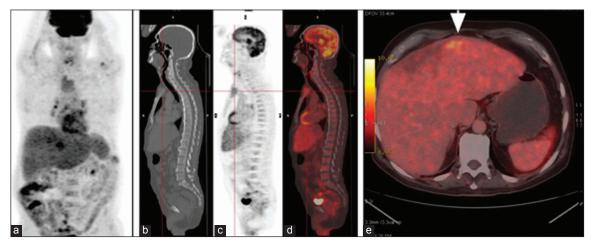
F-18 fluorodeoxyglucose positron emission tomography images (a) maximum intensity projection shows increased tracer uptake in the primary hepatocellular carcinoma (arrow) and also in the manubrium sternum (curved arrow). Sagittal images (b) computed tomography, (c) positron emission tomography, (d) PET/CT images show FDG uptake in the osteolytic lesion with soft tissue mass in the manubrium sterni with no other abnormal uptake elsewhere in the body. Transaxial PET/CT image (e) of the abdomen shows focal FDG accumulation (arrow) in the periphery of the hypodense lesion, a primary tumour in the liver
